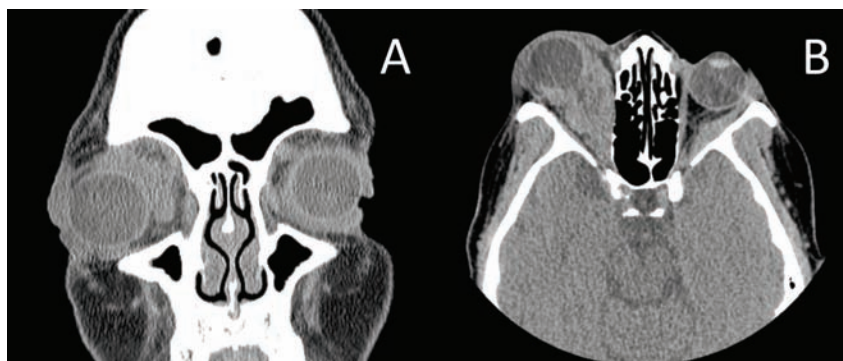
Computed tomography of the orbits without contrast. Coronal (A) and axial (B) views.
